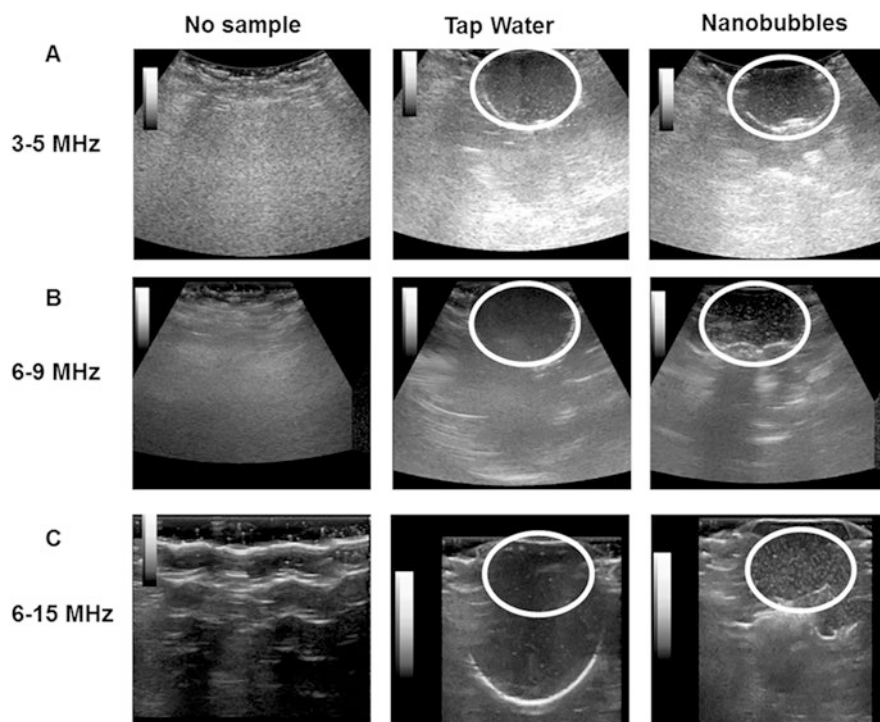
Ultrasound images of ONBs. No sample, tap water, and nanobubbles were compared. (a) Images with a 3–5 MHz transducer. (b) Images for a 6–9 MHz transducer. (c) Images with a 6–15 MHz transducer [23]
